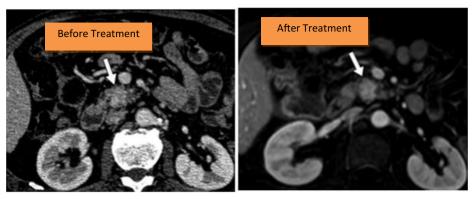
CT Scan image shows the tumor before and after treatment
